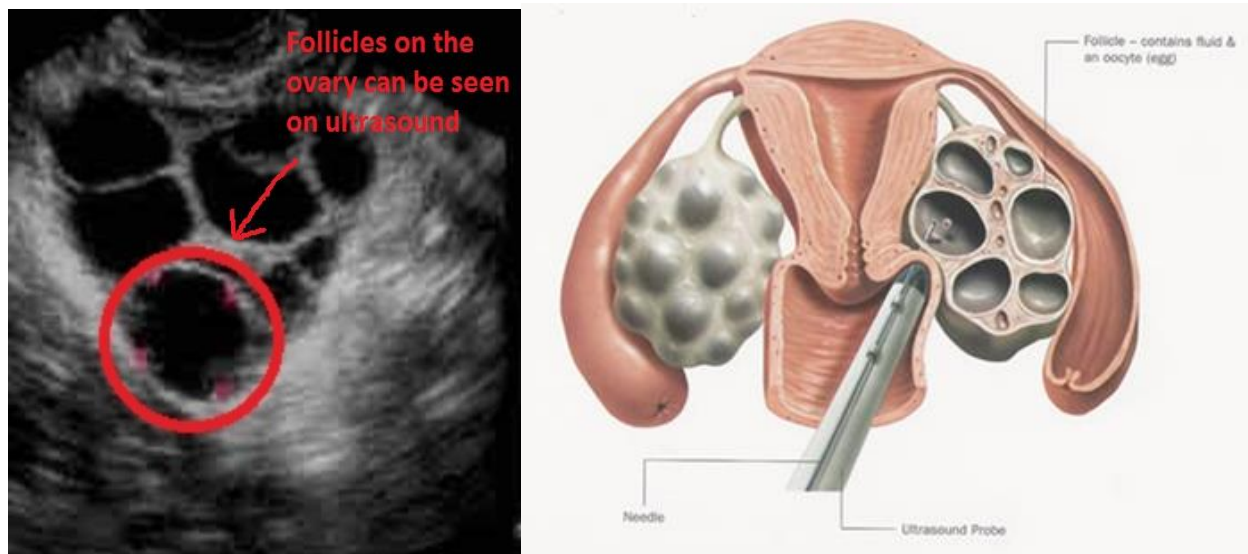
Mature follicles as seen on a transvaginal ultrasound (Thamari Fertility centre., 2015)
